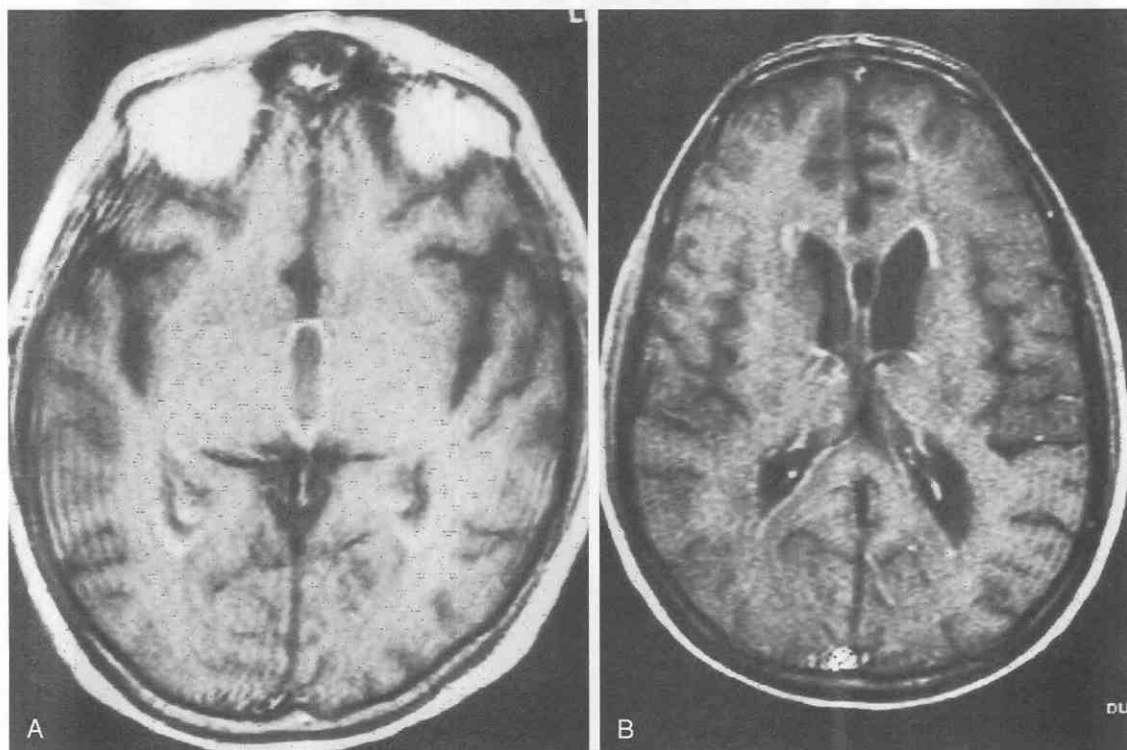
Ependymitis. *A* and *B*, Gadolinium-enhanced MRI study shows thin, smooth ependymal enhancement in an AIDS patient with cytomegalovirus ependymitis.
